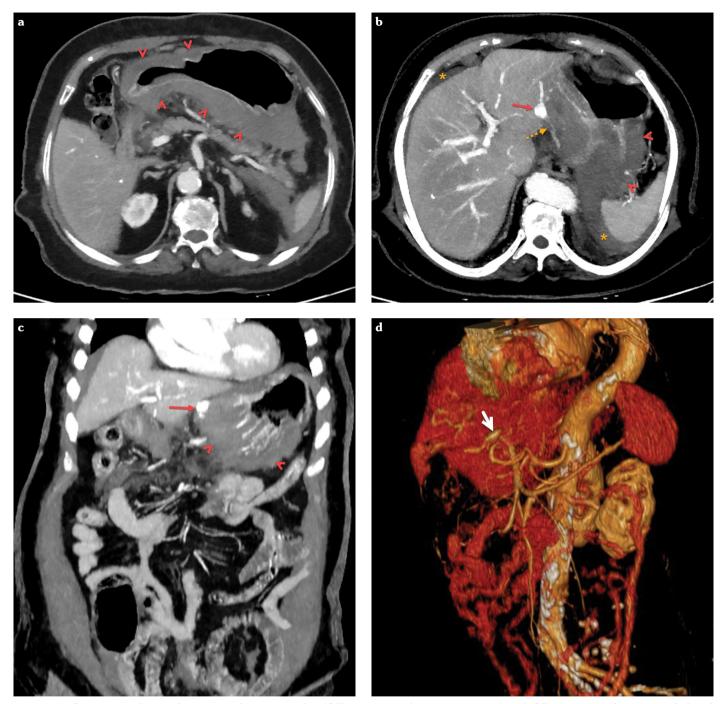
Contrast-enhanced computed tomography (CT) angiography images. (a) Axial CT image at the stomach level shows diffuse wall thickening affecting the entire stomach, suggesting malignancy (arrowheads). (b) Axial CT image at the level of left liver lobe demonstrates gastroepiploic artery aneurysm (red arrow) and abdominal free fluid with high attenuation (*) compatible with hemoperitoneum. Note the diffuse gastric wall thickening (arrowheads) and wall irregularities in the gastroepiploic artery (dashed arrow). (c) Coronal CT image shows diffuse gastric wall thickening (arrowheads) and gastroepiploic artery aneurysm (red arrow). (d) Three-dimensional volume CT image shows the fusiform aneurysm of gastroepiploic artery (arrow)
